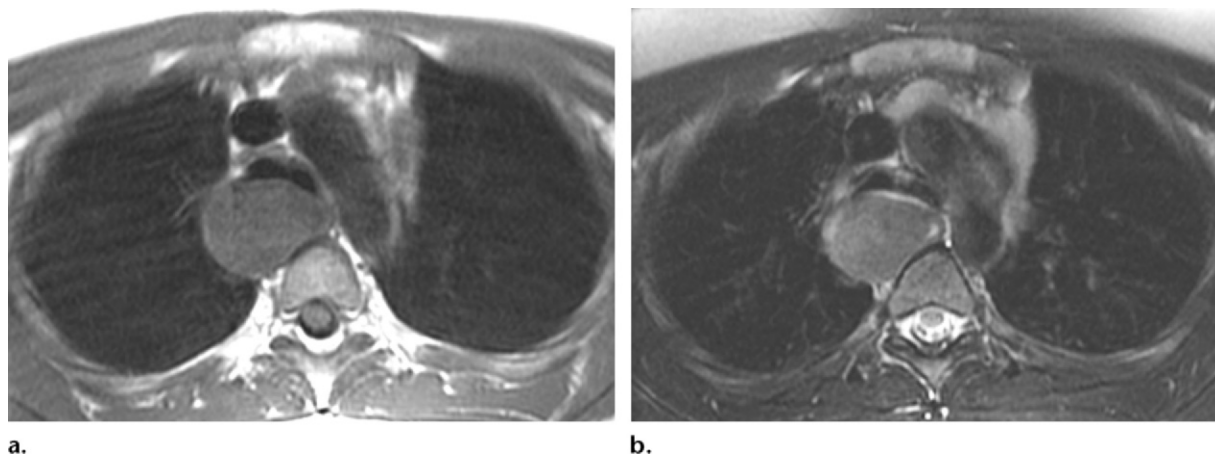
Esophageal leiomyoma in a 14-year-old girl with a 5-year history of dysphagia. (a) Axial T1-weighted MR image shows a homogeneous midesophageal mass that is isointense to muscle. (b) On an axial T2-weighted MR image, the mass has homogeneous signal intensity that is slightly hyperintense to that of muscle.
